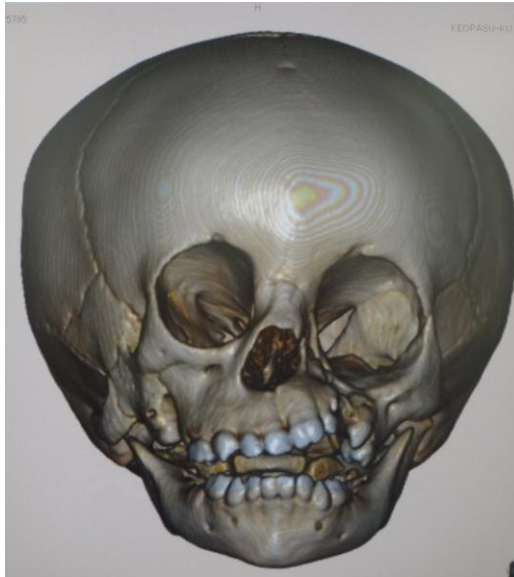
Computed tomography revealed the left maxillary bone and orbital floor defect.
